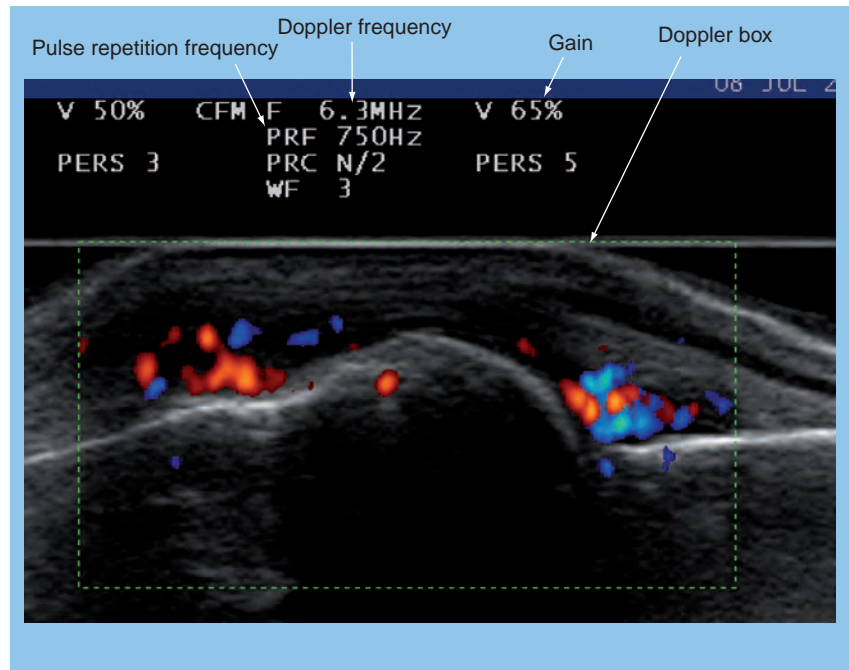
Doppler settings (dorsal longitudinal scan of a metacarpophalangeal joint).
